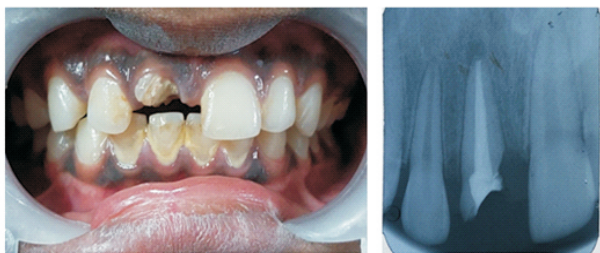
Clinical photograph and radiograph before extrusion
